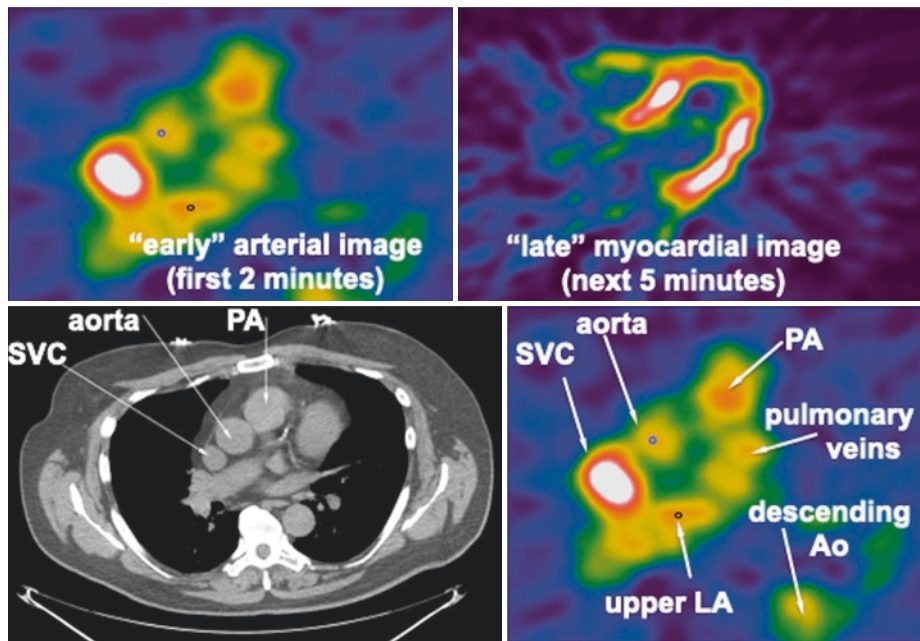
PET and CT views of arterial activity and anatomy. Although not used for locating the arterial ROI, for teaching purposes the CT scan documents the structures as seen in slice B of Fig. 6.34 [2, 58]
